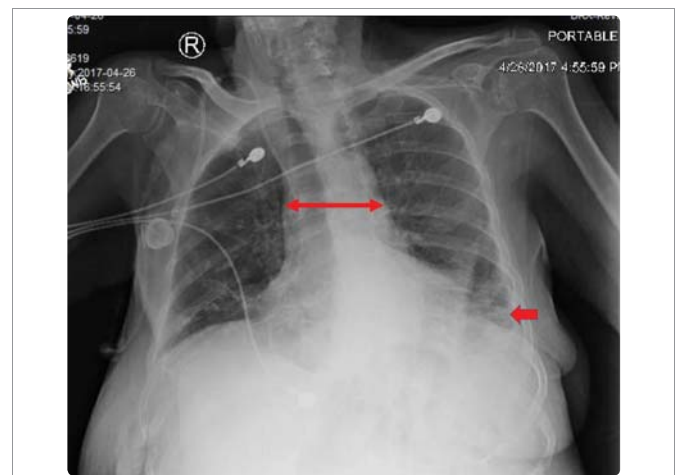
Chest radiograph revealing a widened mediastinum (long arrow). Also note absence of fundic gas bubble (short arrow).
